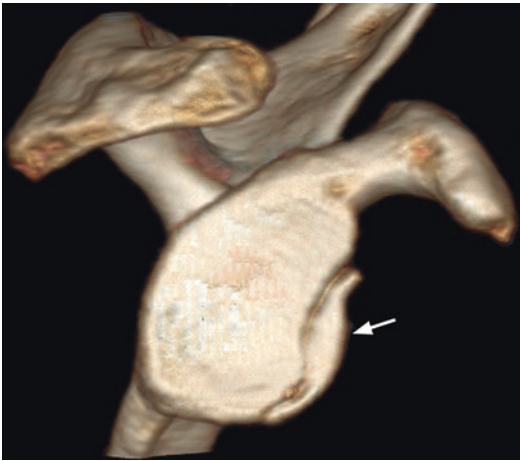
3D CT reconstruction of shoulder in patient with anterior dislocation showing large fracture (arrow) of anterior glenoid rim. 3D allows very good perception of fracture fragments. The humeral head has been electronically disarticulated to allow an unobstructed clear en face view of the glenoid
